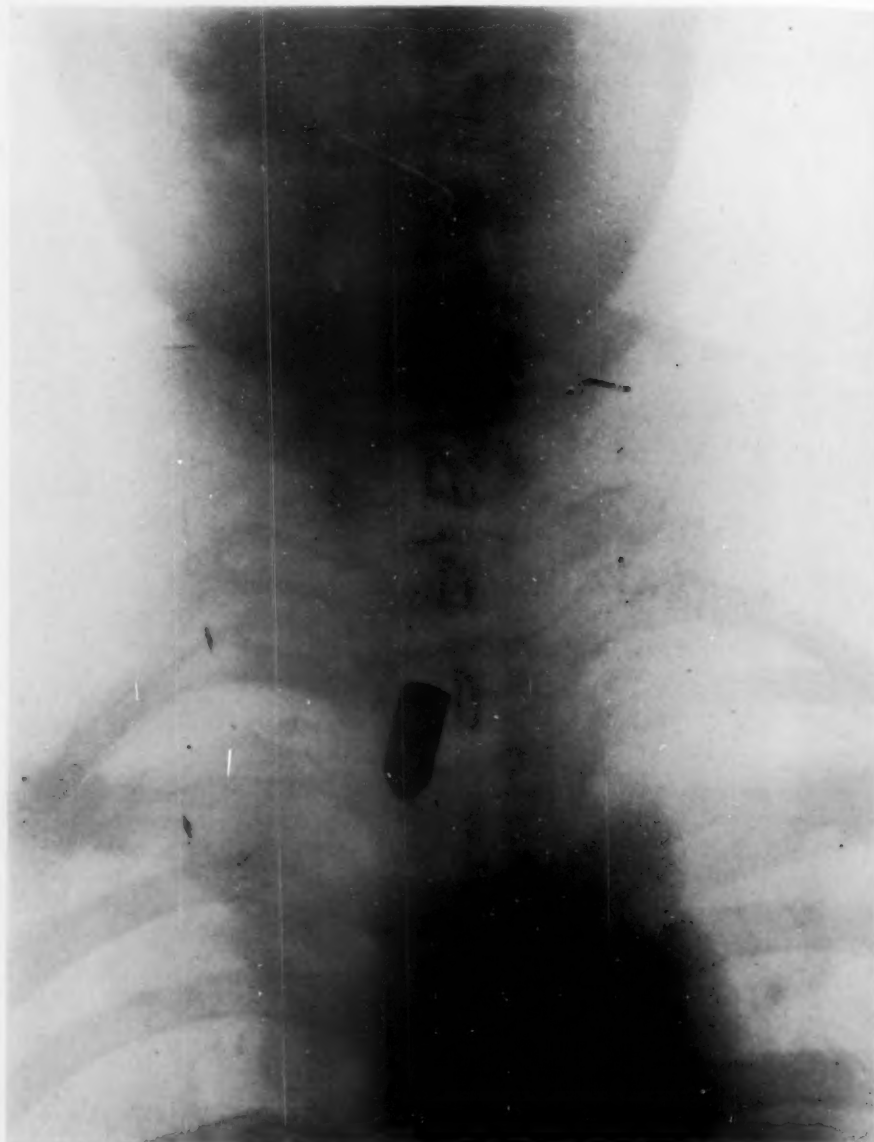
X-ray picture of a bullet embedded in the deep muscles of the neck for forty-five years (Case II).
